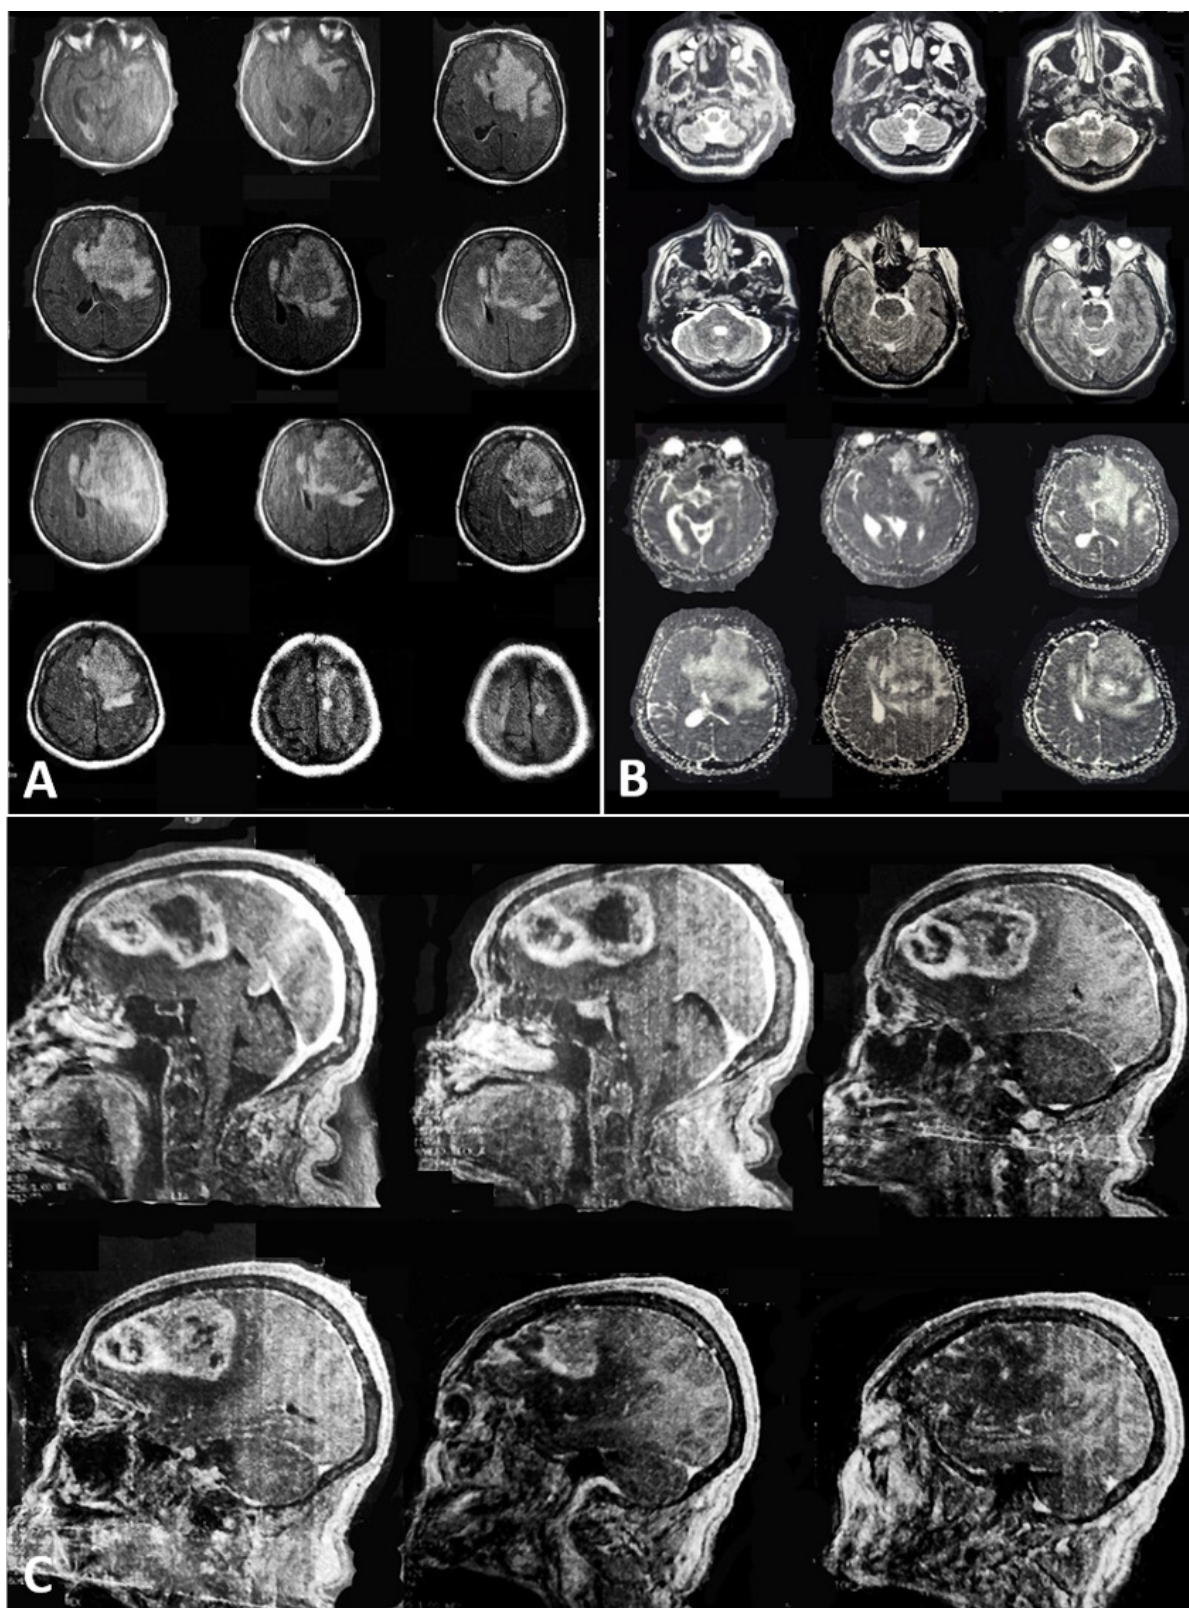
MRI. A. Axial Flair. B. Axial T2. C. Sagittal FLAIR. MRI showing the described lesion, infiltrative, invasive, with necrotic center and perilesional edema, accompanied by significant mass effect and anterior transcallosal expansion to the right hemisphere.
